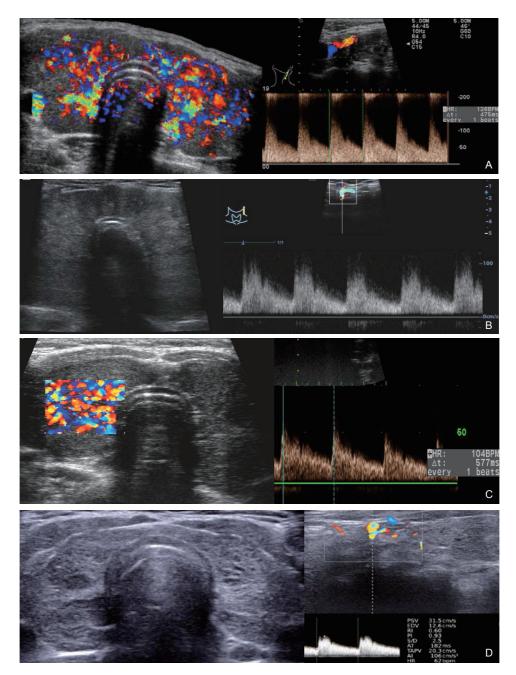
(A) Ultrasound imaging showing the Type A with high peak velocity of STA and fast HR. (B) Ultrasound imaging showing the Type B with high peak velocity of STA and normal HR. (C) Ultrasound imaging showing the Type C with normal peak velocity of STA and fast HR. (D) Ultrasound imaging showing the Type D with normal peak velocity and normal HR.
